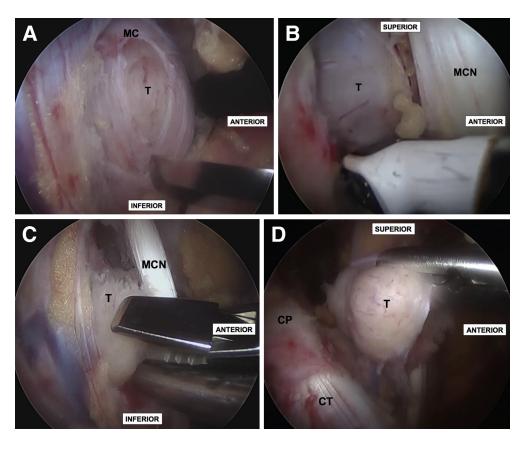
Arthroscopic dissection of the intraneural mass of the right shoulder. With the patient in the beach chair position, using the medial portals, a longitudinal incision of the medial cord (MC) is performed with a long beaver blade (A) to expose the tumor (B). Arthroscopic grasper and smooth dissector are successively used to dissect the tumor (T) away from the cord (C) and remove it through the instrumental portal (D). (CP, coracoid process; CT, conjoint tendon; MCN, musculocutaneous nerve).
